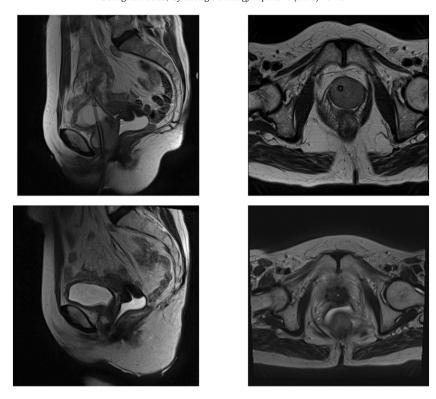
Upper row: T2-weighted sagittal and axial MRI at initial diagnosis revealing a 4 cm periurethral mass with a Foley catheter traversing the lesion. The lesion is diffusely enhancing with some areas of hyperintensity. Lower row: T2-weighted sagittal and axial MRI at 5 months post-treatment, revealing no discrete or identifiable periurethral mass, and no regional lymphadenopathy to suggest recurrence.
